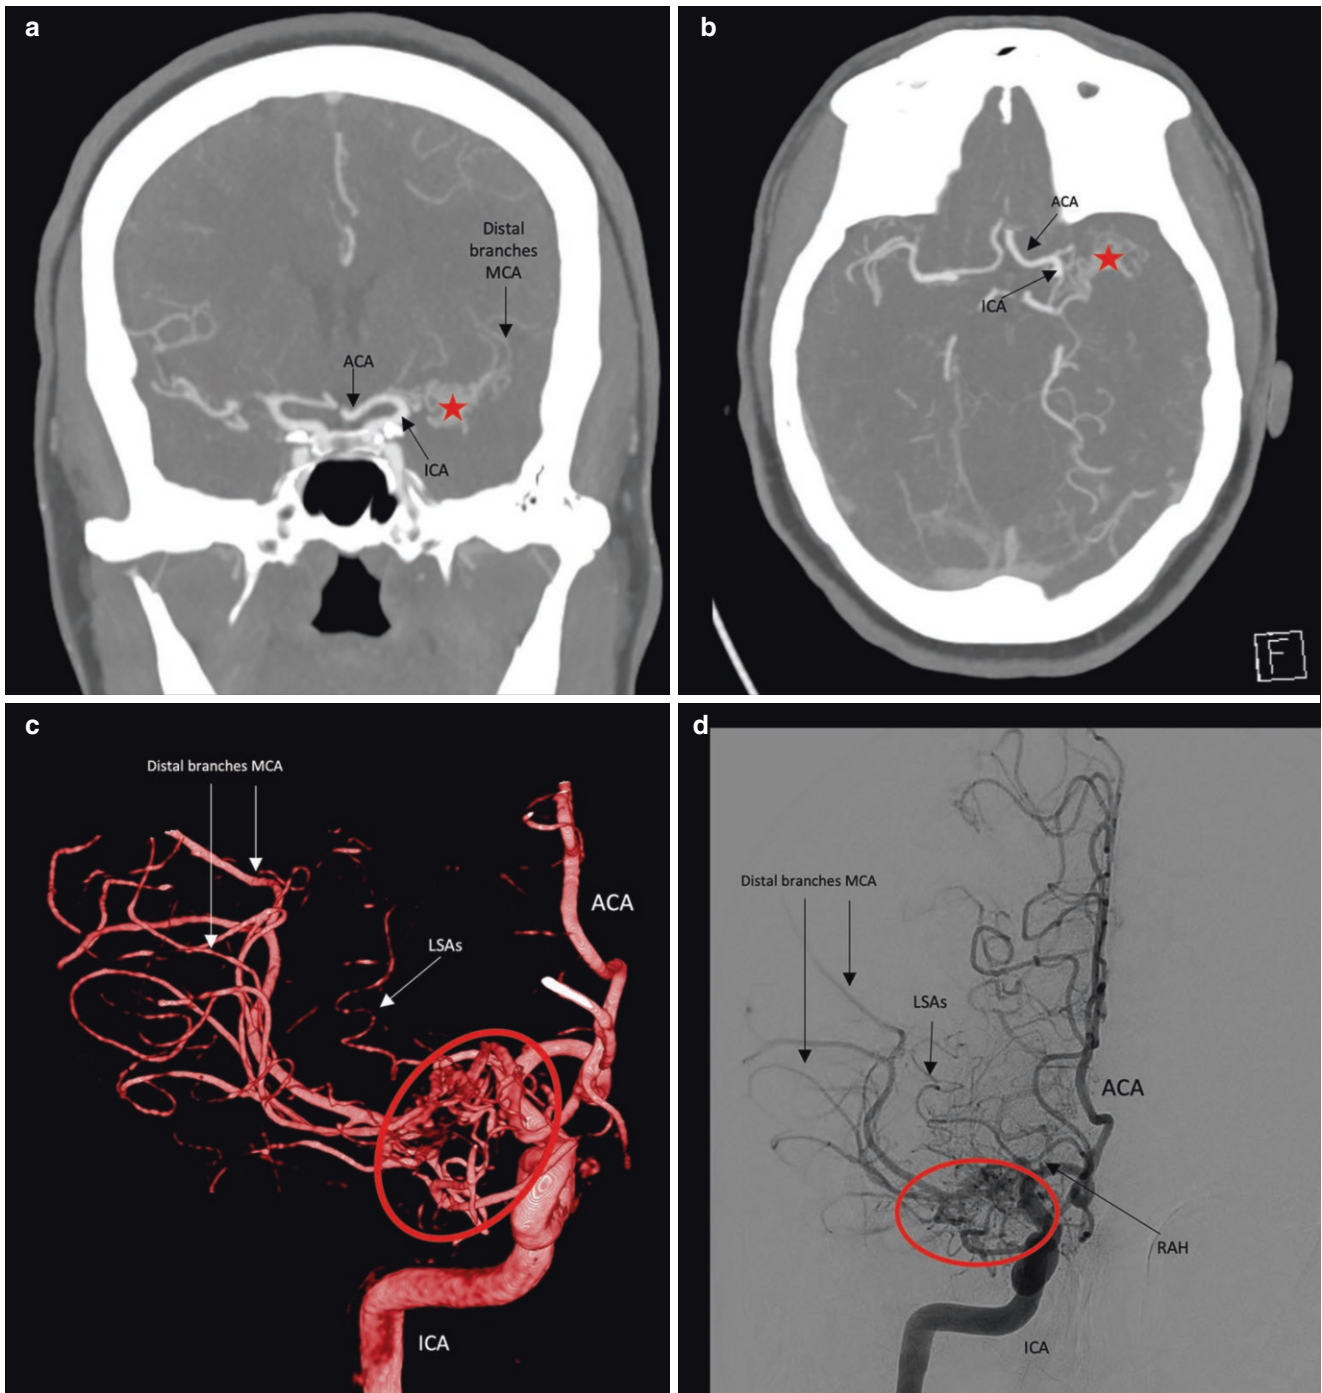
Clinical cases of Twig-like MCA. Figures (a and b) show the case of a patient with a twig-like MCA on the left side, shown through an Angio-CT scan. After the internal carotid artery (ICA) bifurcation, the anterior cerebral artery (ACA) is clearly visible, while the middle cerebral artery appears as a plexiform arterial network (red star). Figures (c and d) show a second case of the same variant on the right
